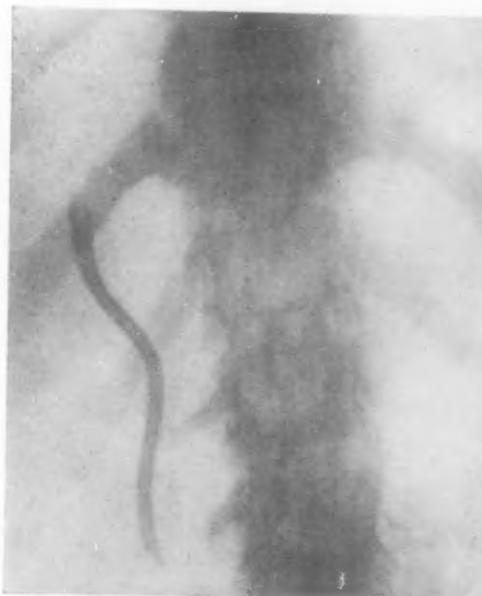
Shows X-ray picture of tube in the common duct. This was one of the earlier cases operated and took nine weeks to be discharged via the intestines.
